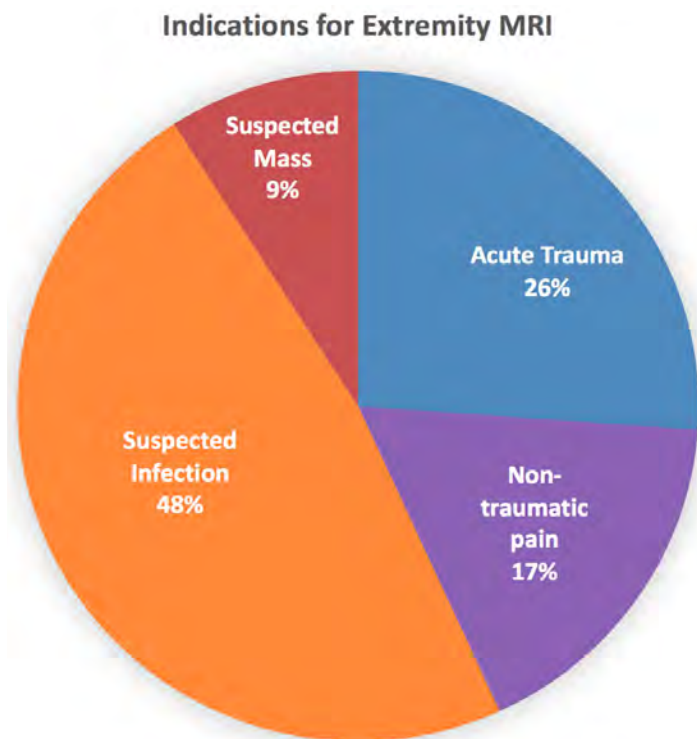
Distribution of indications for musculoskeletal extremity magnetic resonance imaging (MRI) in the emergency department observation unit.
